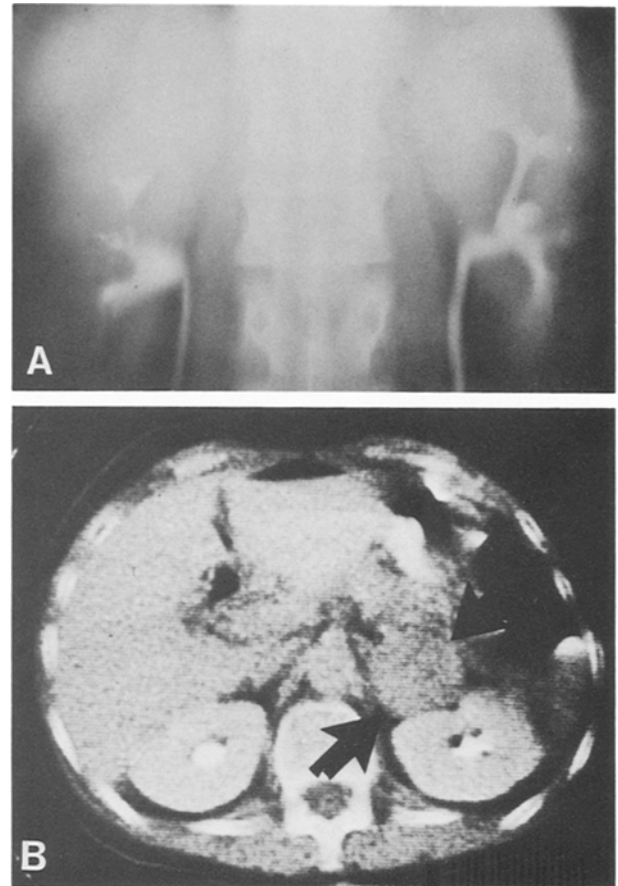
A non-revealing IVP nephrotomogram (A) was followed by a convincing CT scan imaging of a left adrenal pheochromocytoma (B) in a patient with convincing biochemical proof of the diagnosis. The adrenal venogram of this mass is seen in Fig. 2.
